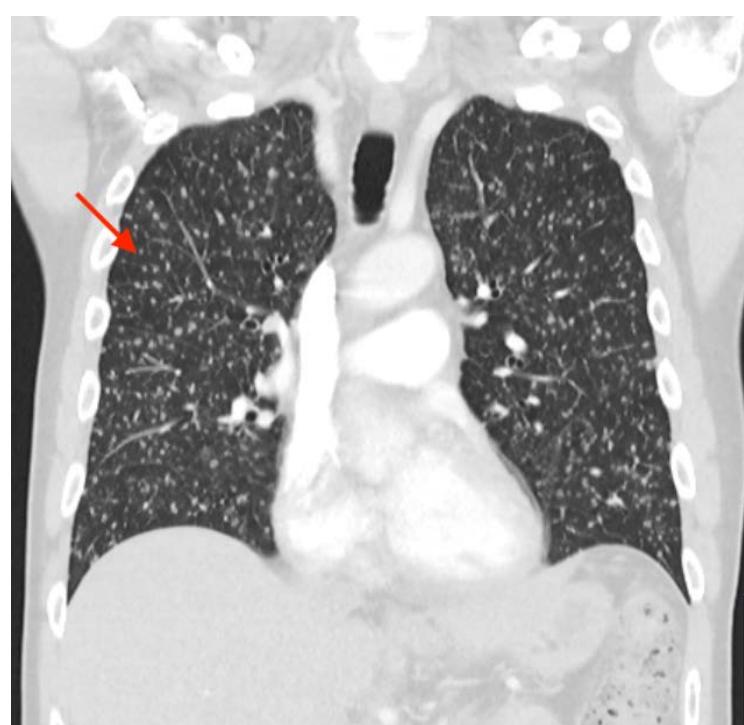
Coronal CT images demonstrate disseminated tuberculosis following BCG therapy. FINDINGS: coronal chest CT shows numerous <2 mm randomly distributed nodules (arrow) involving both lungs concordant with miliary tuberculosis. TECHNIQUE: Coronal contrast-enhanced chest CT using 120 kV, 180 mAs, 1.0 mm slice thickness, 100 mL iodinated contrast medium during venous phase.
